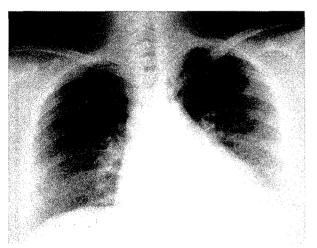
Chest roentgenograph in resolution was obtained 12 days after steroid therapy.
